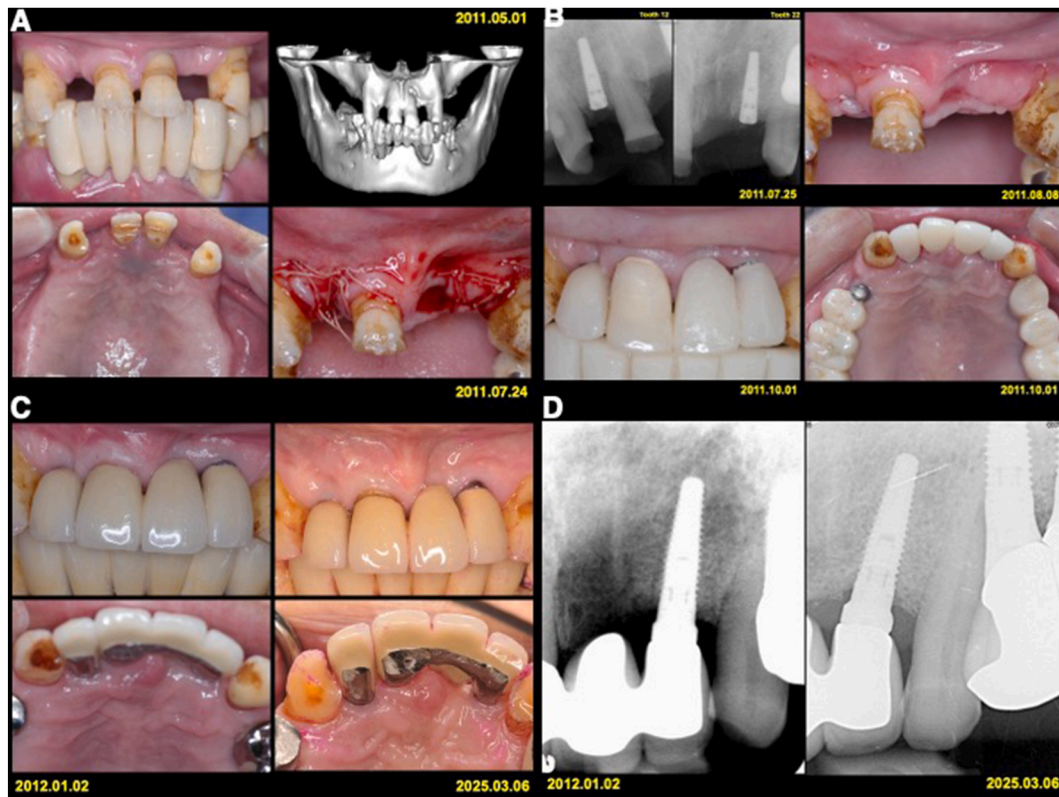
Clinical photographs and radiographs of the patient.
